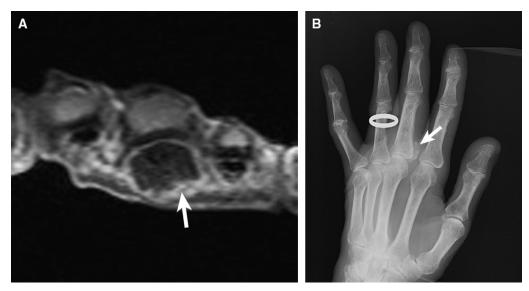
An 86-year-old man with calcific tendinitis of the right long finger. (A) Axial T1 MR image of the right hand at the level of the metacarpophalangeal (MCP) joints shows marked enlargement of the flexor tendon to the long finger (arrows), with oedema in the tendon and surrounding subcutaneous tissues. (B) Corresponding oblique hand radiograph shows focus of ill-defined calcification in the flexor tendon (arrow).
